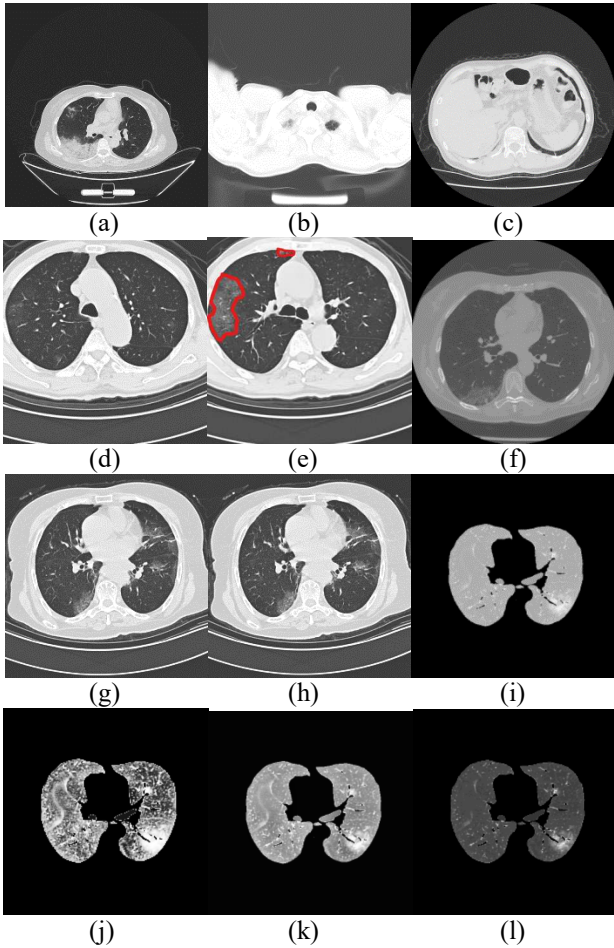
(a) High-contrast CT, (b) NI-CT slice, (c) small lung regions CT, (d)-(e) CT slices without and with signs of GGO from the same patient. (f) low-contrast CT, (g)-(h) adjacent CT slices which share virtually similar spatial representation, (i) segmented image, (j) image with histogram equalization, (k) CLAHE, (l) supervised gamma adjustment.
